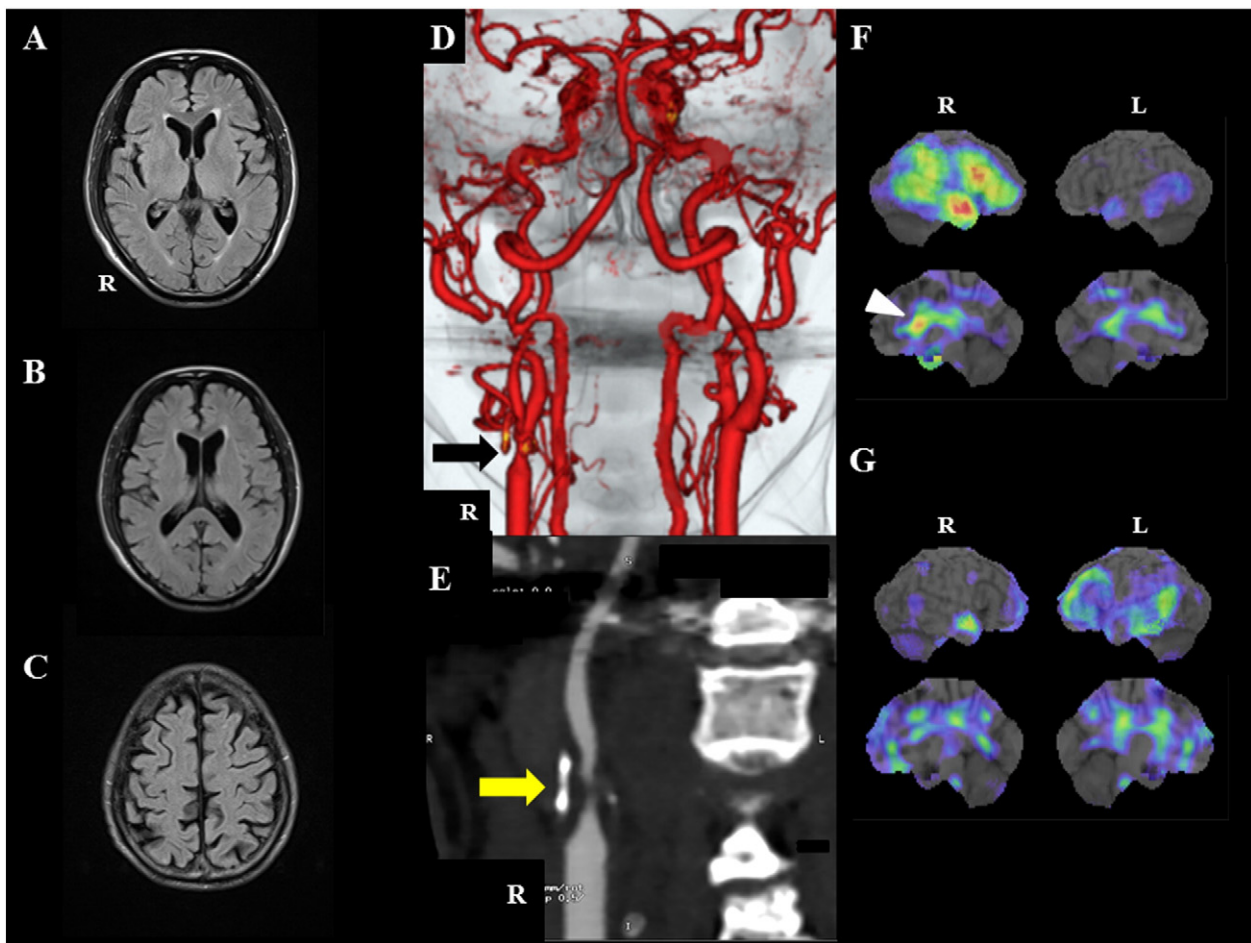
(A–C) Axial fluid-attenuated inversion recovery images showing no ischemic lesions in basal ganglia, subcortical white matter and cerebral cortices. (D and E) Computed tomography angiography (CTA) images showing severe stenosis of the right internal carotid artery (arrows). (F) Preoperative ^{123}I -IMP SPECT images showing hypoperfusion in right hemisphere including the caudate (arrowhead). (G) Postoperative ^{123}I -IMP SPECT images showing improvement of perfusion in previously affected areas.
